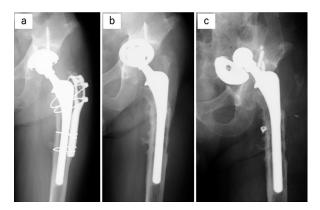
Case 2. Anteroposterior radiographs of the left hip at 8 (a), 16 (b), and 17 (c) years after THA. Periprosthetic osteolysis caused a severe bone defect and implant failure.
